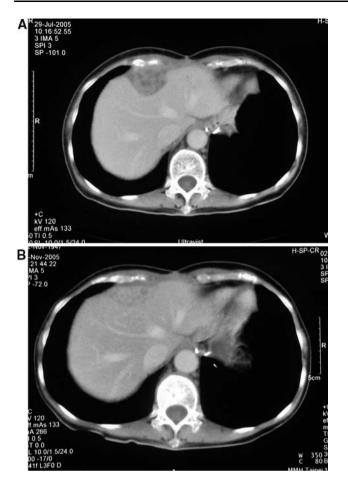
Computed tomography of the abdomen of case 3. (a) Before discontinuation of imatinib showing a new hepatic metastatic tumor at the anterior aspect of hepatic dome $(4.4 \times 3.1 \text{ cm})$. (b) 9 weeks after the withdrawal of imatinib showing spontaneous partial regression of the metastatic hepatic tumor $(4.3 \times 1.8 \text{ cm})$
